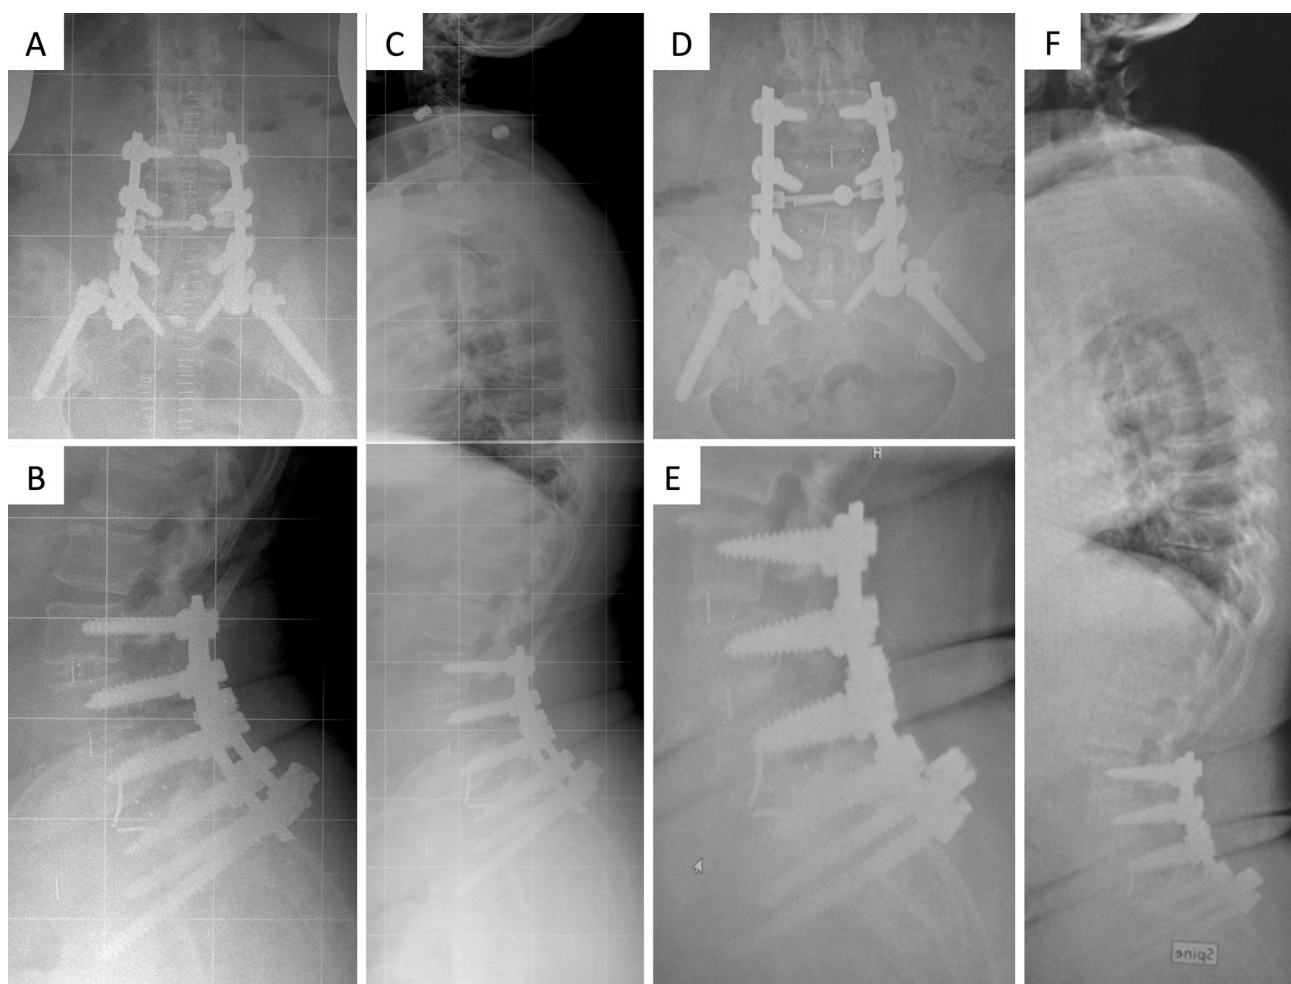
Post-operative radiographs after undergoing a L5–S1 anterior lumbar interbody fusion, L5 laminectomy, and extension of instrumented fusion to the pelvis demonstrated reduction of the L5–S1 spondylolisthesis to grade 1 and excellent restoration of regional and sagittal alignment [pelvic incidence (PI): 58°; lumbar lordosis (LL):
